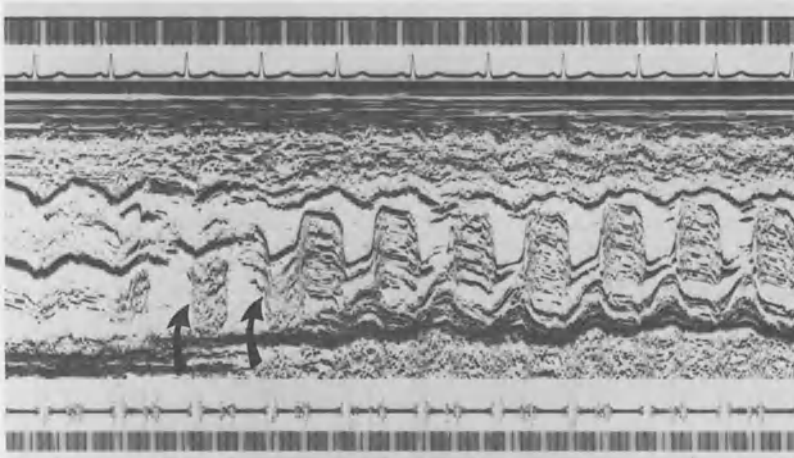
M-Mode echocardiogram in left atrial myxoma. There is a mass of echoes behind the anterior mitral leaflet: The tumor prolapses into the left atrium (arrows).
